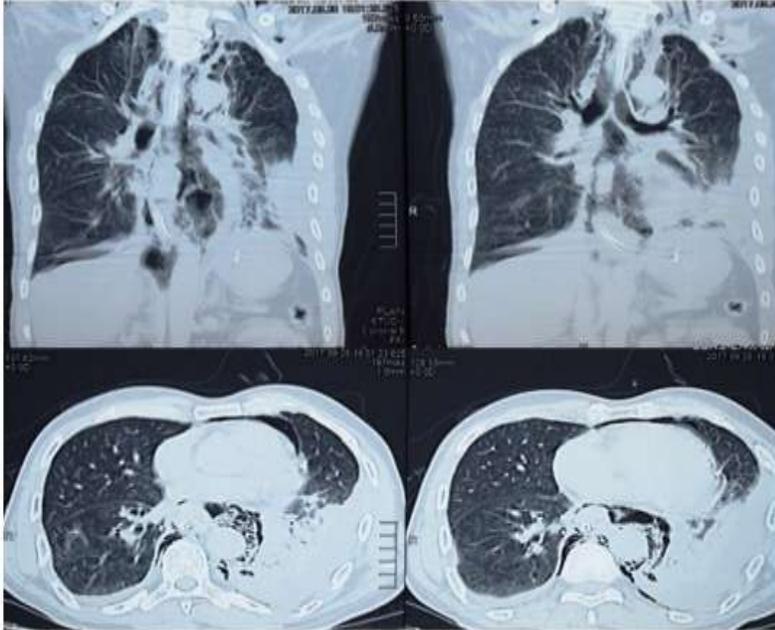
CT scan Chest showed collapse consolidation of left lower lobe with pleural & mediastinal emphysema along with subcutaneous emphysema of neck & left lateral chest.
